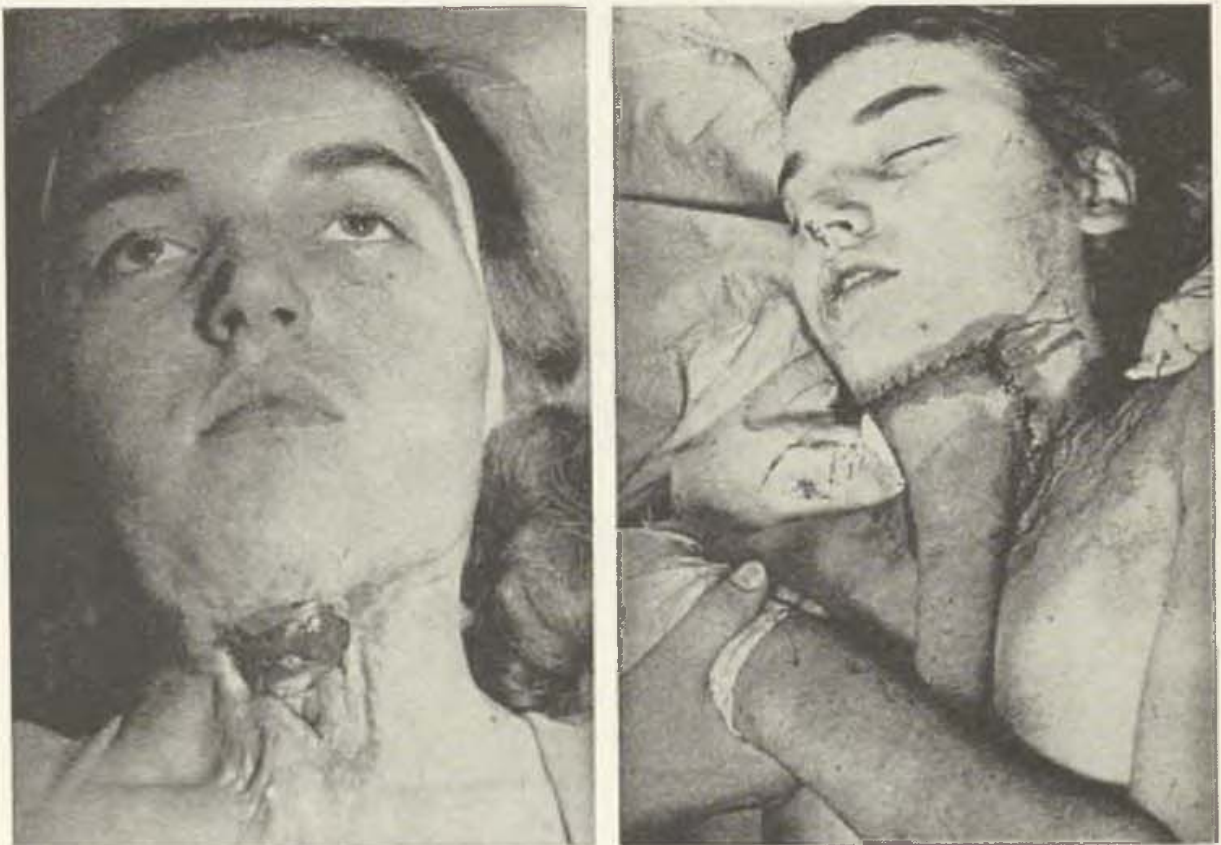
Fibrotic encasement by scar tissue of anterior aspect of neck with central ulcer due to repeated surgical and X-ray treatment of mentosternal neck fistula. — Fig. 5b. Coverage of large tissue defect resulting from excision of massive fibrosis with tubed pedicle flap from abdomen.
